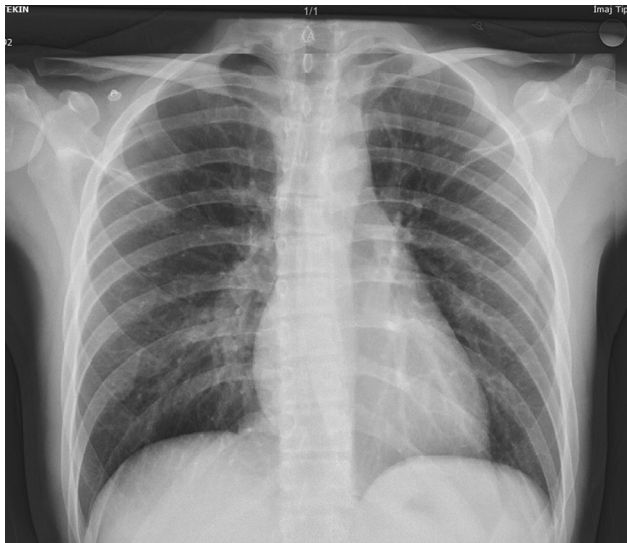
There is no detectable pneumothorax on APCXR. APCXR: anteroposterior chest X-ray
